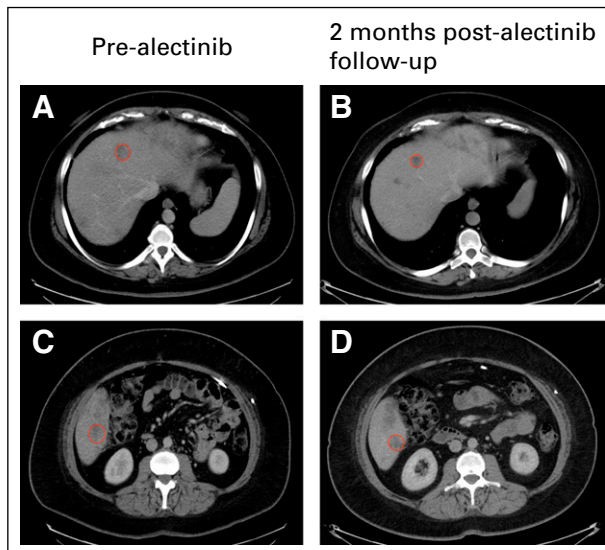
Computed tomography imaging of hepatic metastasis before and after alectinib. In row 1, the circled hepatic lesion in the right lobe of the liver at baseline (A) before alectinib decreased in size (B) 2 months after alectinib. Similarly, row 2 shows a different metastatic hepatic lesion (C) before alectinib with continued response seen (D) after 2 months of alectinib. The patient experienced progression during alectinib treatment after 5 months and experienced progression during fluorouracil, folic acid, oxaliplatin, and irinotecan treatment shortly thereafter.
